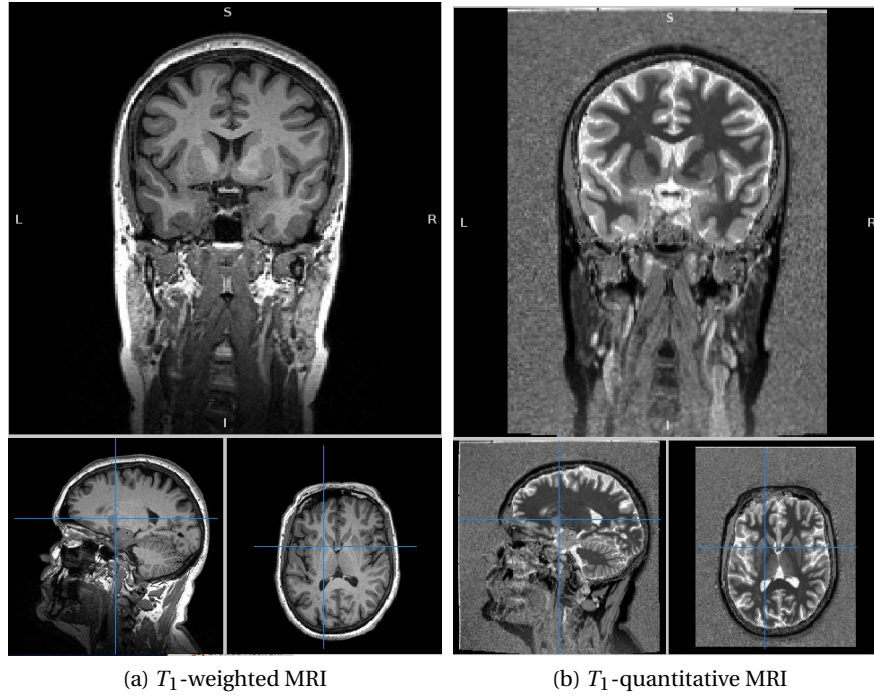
(a) T_1 -weighted MRI, (b) T_1 -quantitative MRI, got from Lausanne Database
